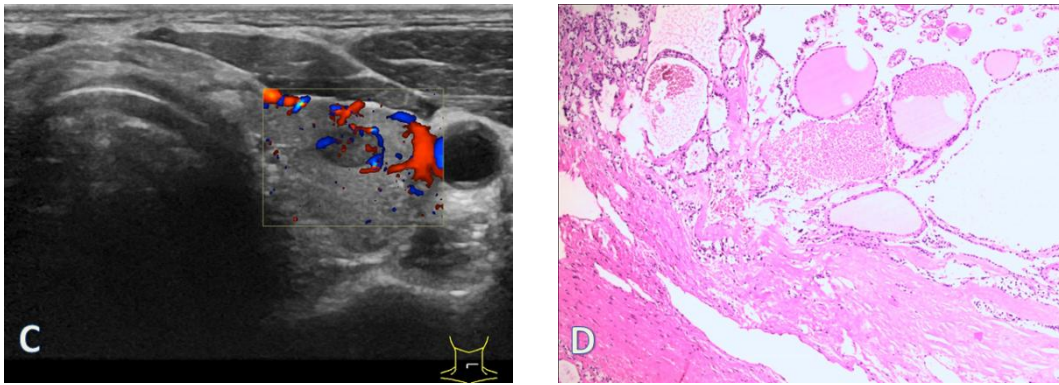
Ultrasonography of cystic nodular goiter in a 54-year-old male patient.
